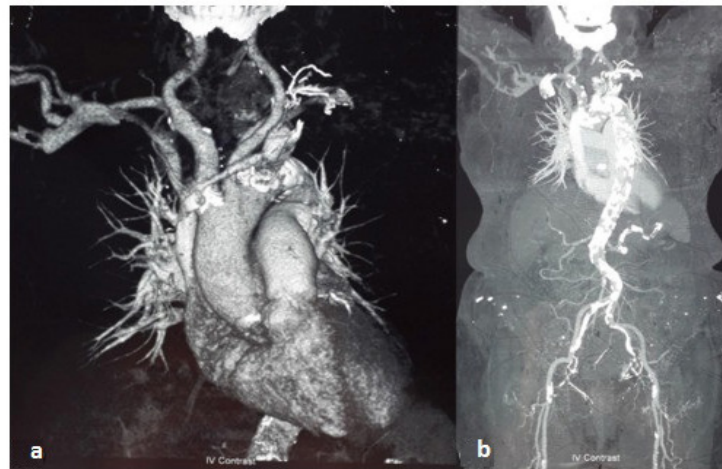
Computed tomographic angiography images of the (a) chest and (b) body.
